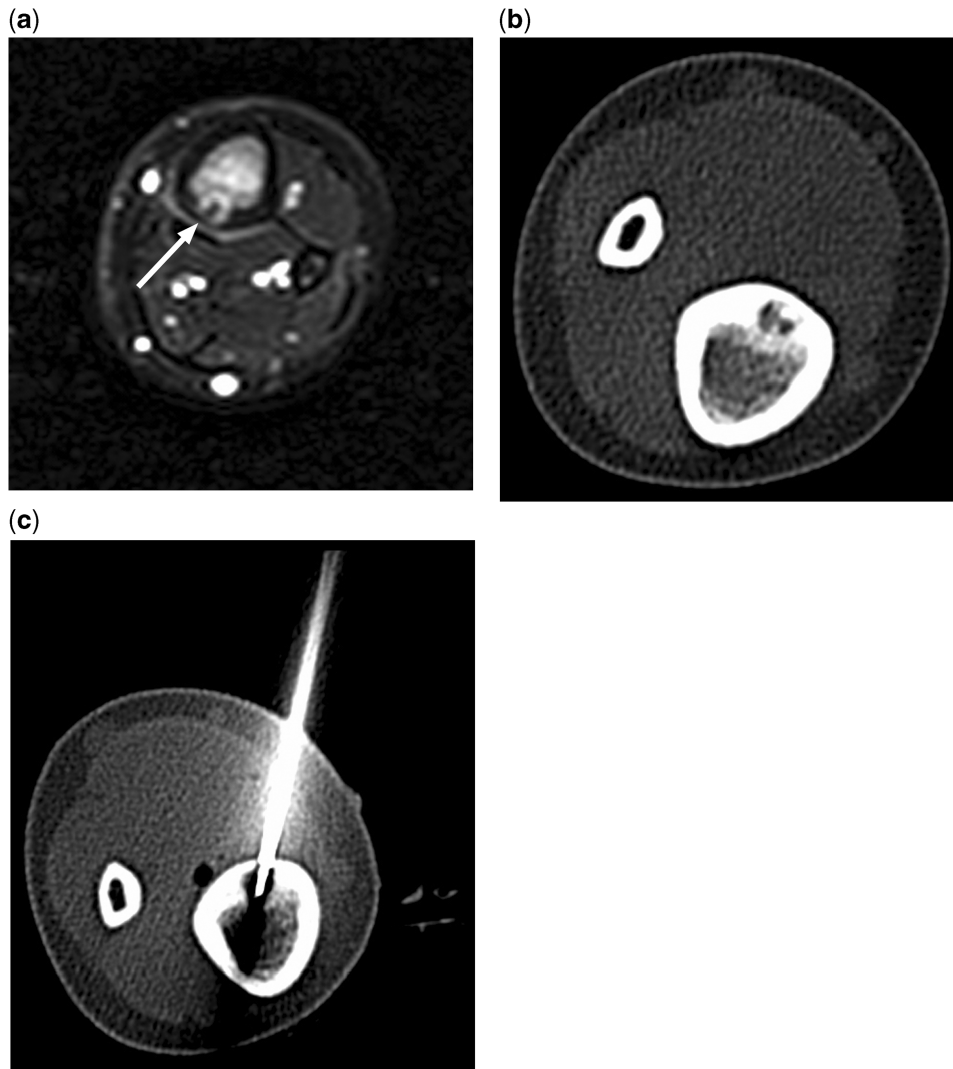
Radiofrequency ablation of an osteoid osteoma in an 11-year-old boy. (a) Transverse T2-weighted MR image shows very high signal in the marrow of the distal left tibia, with a nidus (arrow) in the posterior cortex. (b) CT (prone position) confirms the diagnosis of osteoid osteoma. (c) Following access with a Bonopty penetration set (Apriomed AB, Uppsala, Sweden), a radiofrequency ablation probe (Cosman Medical, Burlington, MA, USA) was used to treat the lesion, with complete resolution of symptoms.
